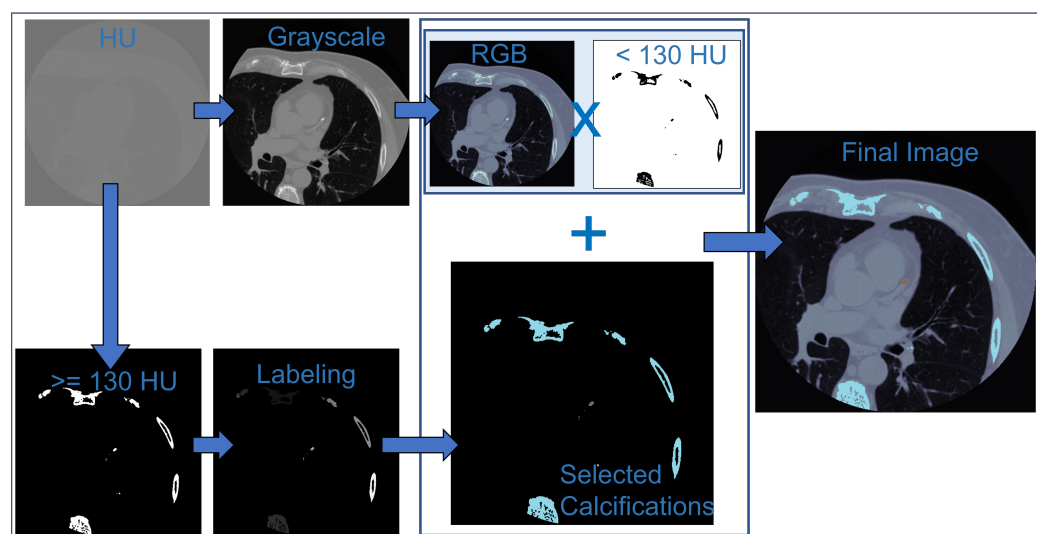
Digital processing of computed tomography images.
